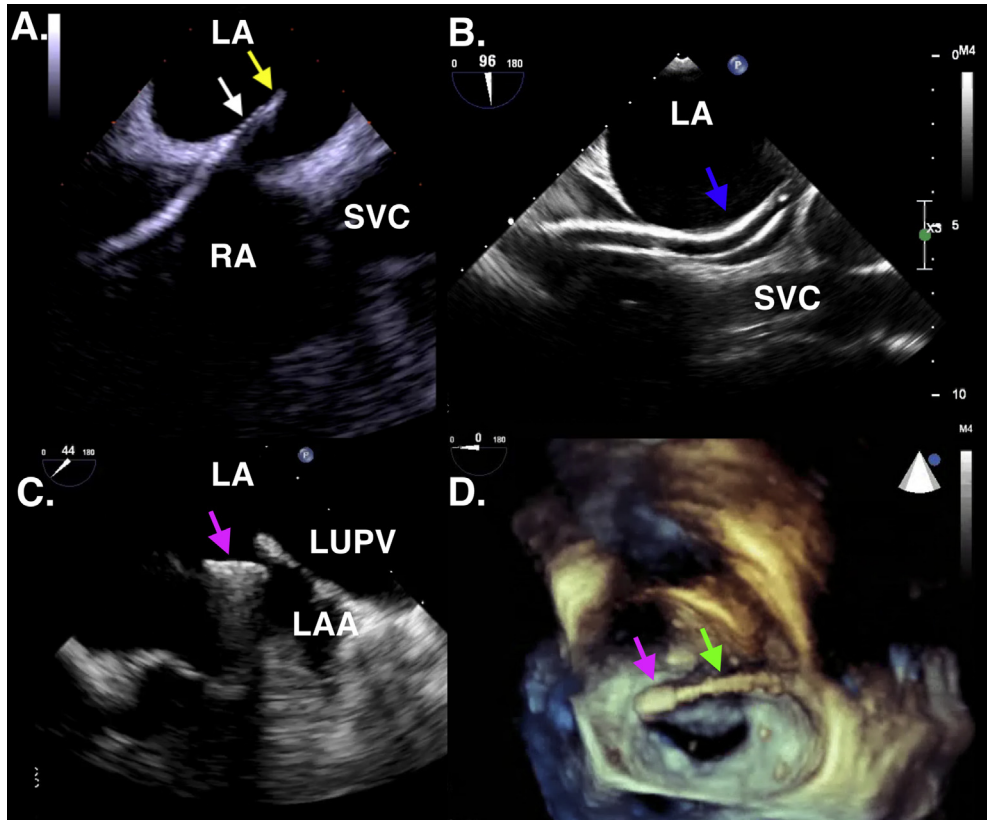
(A) 2D TEE bicaval view of the SGC and its associated grooved dilator (*white arrow*) being advanced over the guide wire (*yellow arrow*) into the LA. (B) 2D TEE bicaval view of the SGC (*blue arrow*) across the IAS. Following removal of the dilator, the distance across the septum can be measured. (C) 2D TEE left atrial appendage view. The clip (*magenta arrow*) can be seen below the Coumadin ridge in close proximity to the left atrial appendage. (D) 3D En face view of the MV clip delivery system (*green arrow*) and the attached clip (*magenta arrow*). The clip's relationship to anatomical structures is clearly seen. The entire system has been withdrawn to avoid injury to the atrial appendage. Constant echocardiographic surveillance will minimize the chance of iatrogenic injury. LAA, Left atrial appendage; LUOV, left upper pulmonary vein; RA, right atrium; SVC, superior vena cava. (See associated [Video 5](#), available at www.onlinejase.com.)
